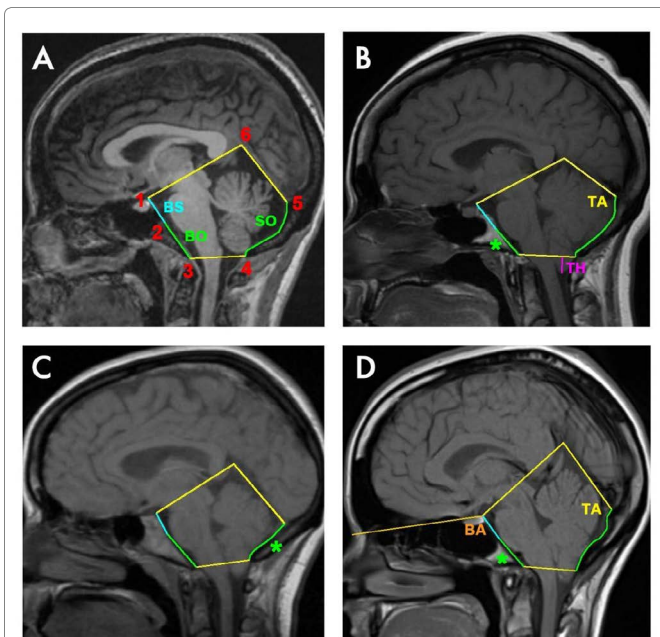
Sagittal T1W1 MRI showing the PCF in four different adult women. In A) Control, B) Classic CM-1 patient with a short basioccipital bone, reduced clivus slope and smaller tentorium angle, C) Classic CM-1 patient with a short supraoccipital bone and smaller tentorium angle, and D) Classic CM-1 patient with a short basioccipital bone, reduced clivus slope and larger tentorium angle. Cerebellum tonsillar herniation (TH) is shown in magenta in B. The occipital bone is shown in green: basioccipital (BO, from 2 to 3) and supraoccipital (SO, from 4 to 5). Basisphenoid (BS, from 1 to 2) with basioccipital results in the clivus (from 1 to 3). The asterisk shows the shorter occipital part in each patient. Tentorium angle (TA) is given by the tentorium cerebelli (from 5 to 6) and supraoccipital bone. Basal angle (BA) > 143° is considered platybasia.
